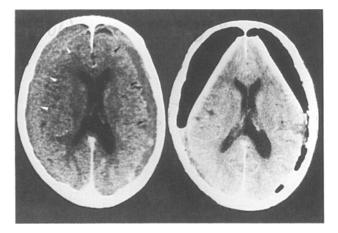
Pre-(left) and postoperative (right) computed tomography scans in a bilateral convexity type. Note complete replacement of the haematoma (arrowheads) with oxygen
